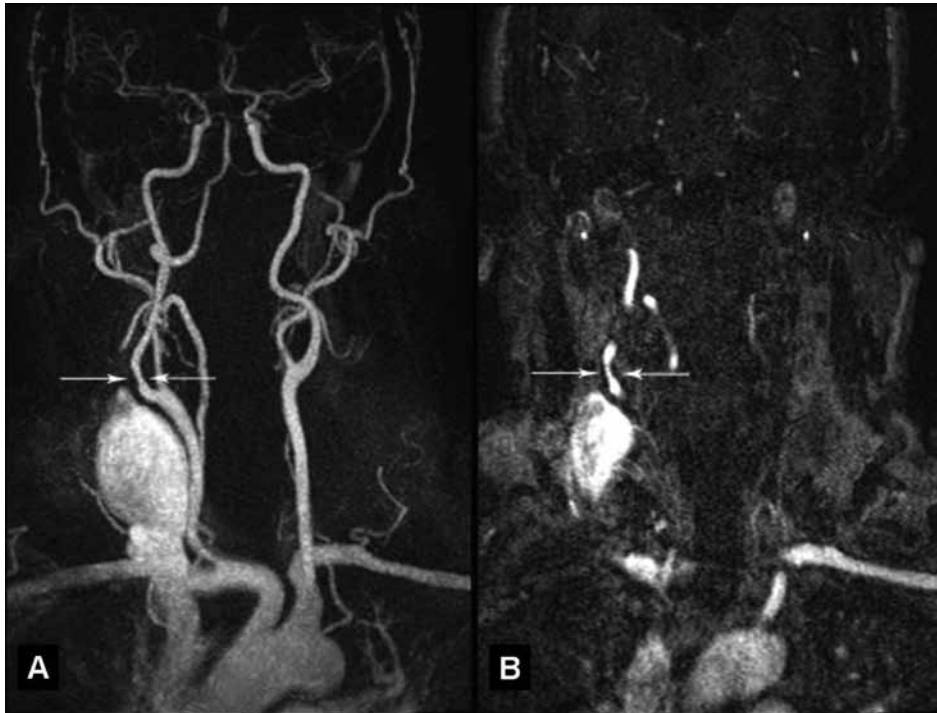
MRI angiographic reconstruction (A) and source image (B) of the carotid arteries. A carotid plaque can be observed at the origin of the right internal carotid artery (arrows).
